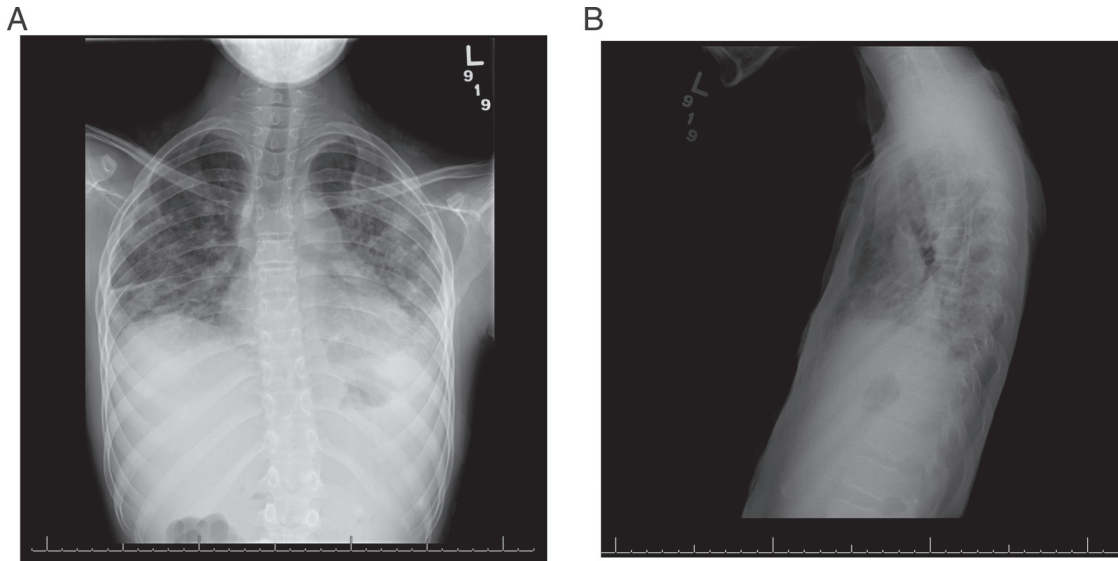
Initial chest radiograph (A) AP and (B) lateral views. Patchy bilateral airspace opacities and bilateral pleural effusions.
